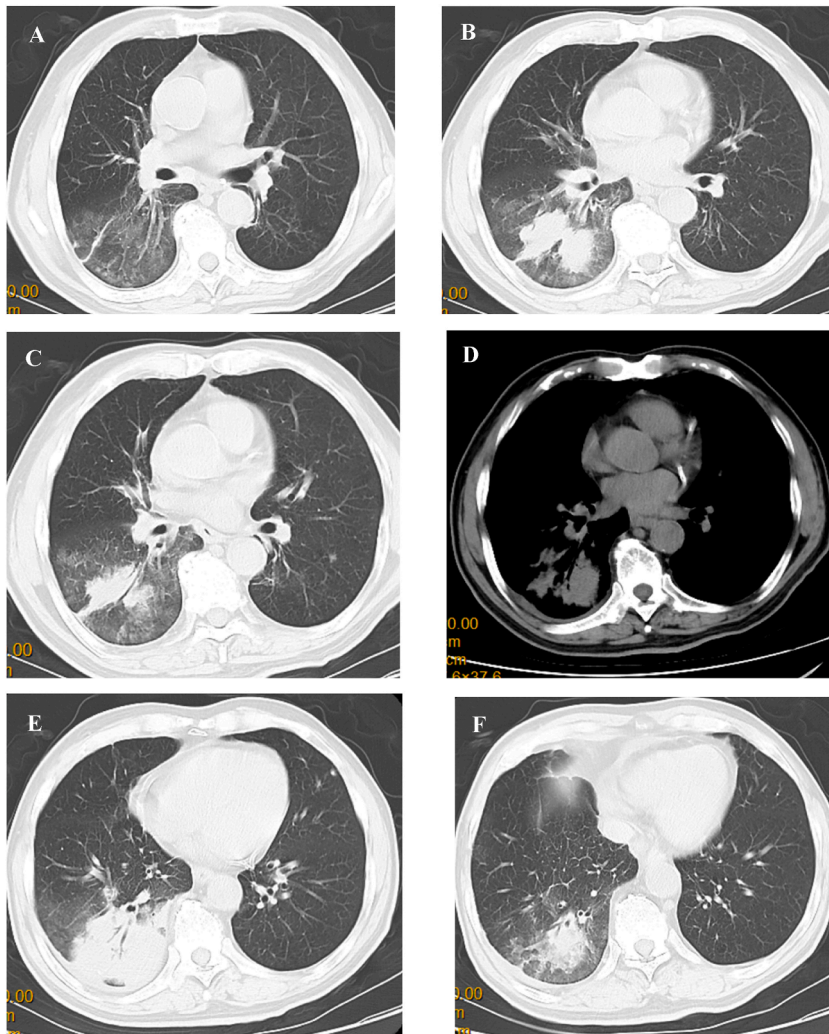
(A–F) CT of the chest showed subpleural high-density shadow in the lower lobe of the right lung, the margin of which was relatively ill defined and ground-glass opacities; pleural effusion and air bronchogram sign were seen in the right lung.
